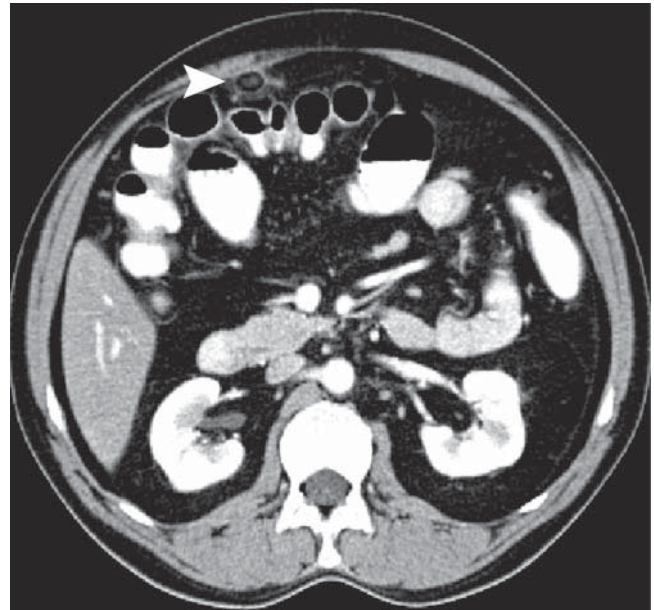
Case 2. Contrast-enhanced computed tomography of the abdomen showing a well-defined fat-containing structure with central hyperdensity (*arrowhead*) arising from the transverse colon
